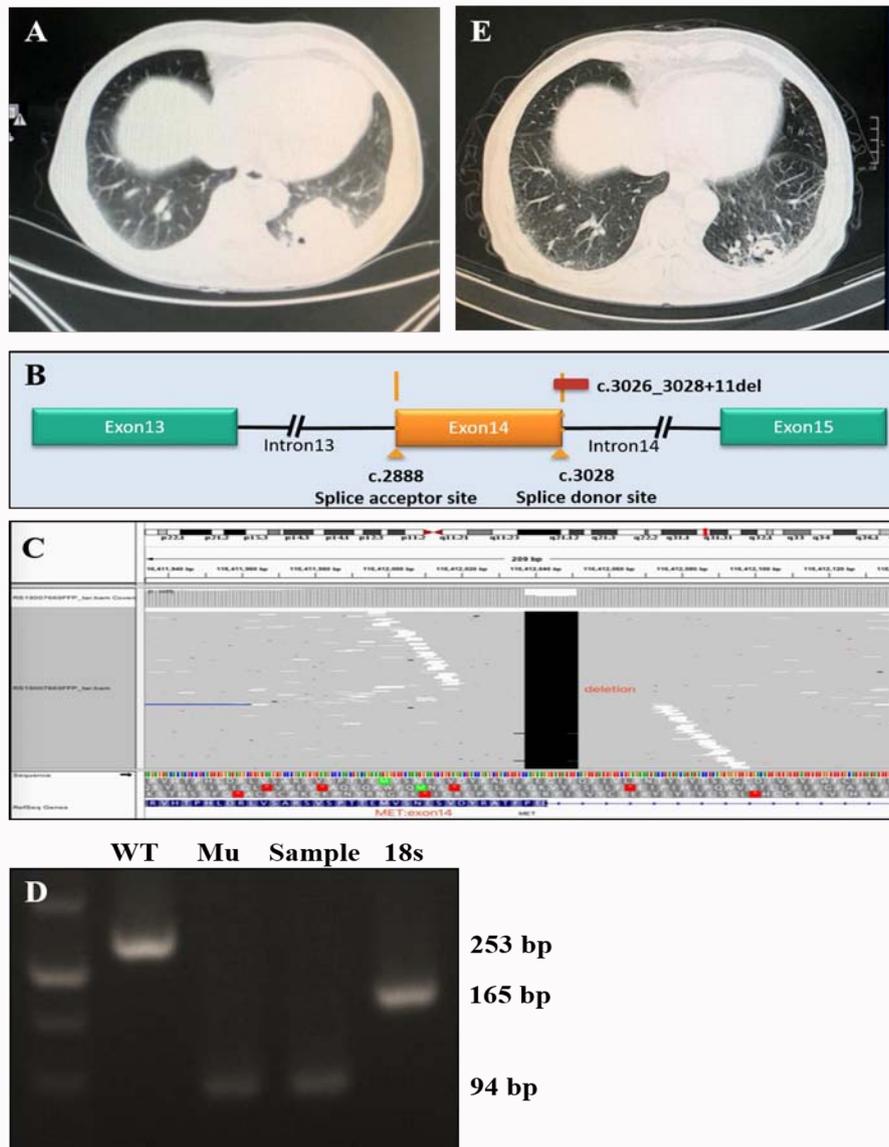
Patient disease diagnosis and treatment. A) chest computed tomography result. B) A MET exon 14 skipping mutation (c.3026_3028+11del) was identified. C) NGS results showing breakpoint of MET exon 14 skipping mutation. D) AMET exon14 skipping H569 cell lines was confirmed by qRT-PCR. E) Tumor response of the patient's left lung after crizotinib treatment.
